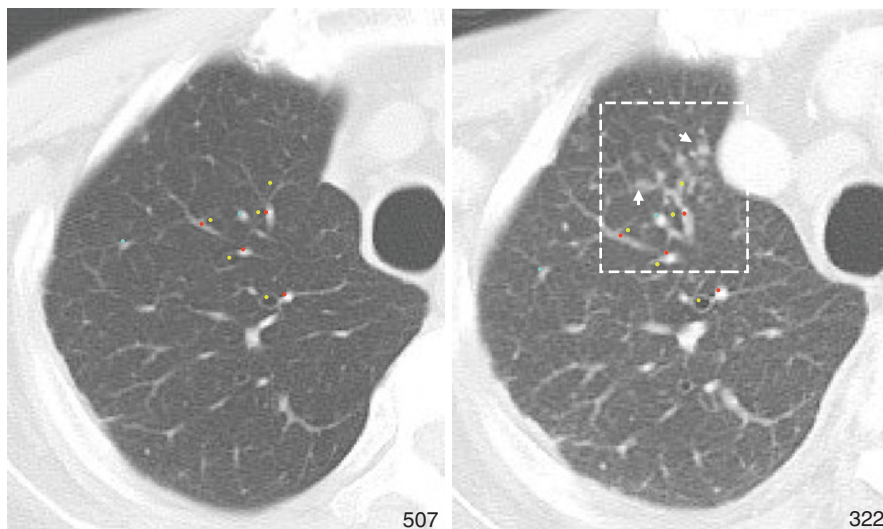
High-resolution computed tomography (HRCT) image of pulmonary TB. HRCT image obtained at the time of the first consultation (left), and 16 months after the diagnosis of pulmonary TB was confirmed (right), showing changes in the upper right lobe in the same region. In the figure on the right, multiple centrilobular and branching nodules (arrows) and thickening of the central bronchial and pulmonary artery bundles connecting them are observed (dotted white rectangular frame on the right). By comparing the right figure with the normal computed tomography figure on the left, the formation and progression of the lesion can be understood. Yellow circles: bronchi; Red circles: pulmonary arteries; Blue circles: pulmonary veins
